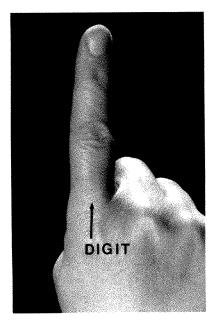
Digit suitable for use in Digital Radiography.
